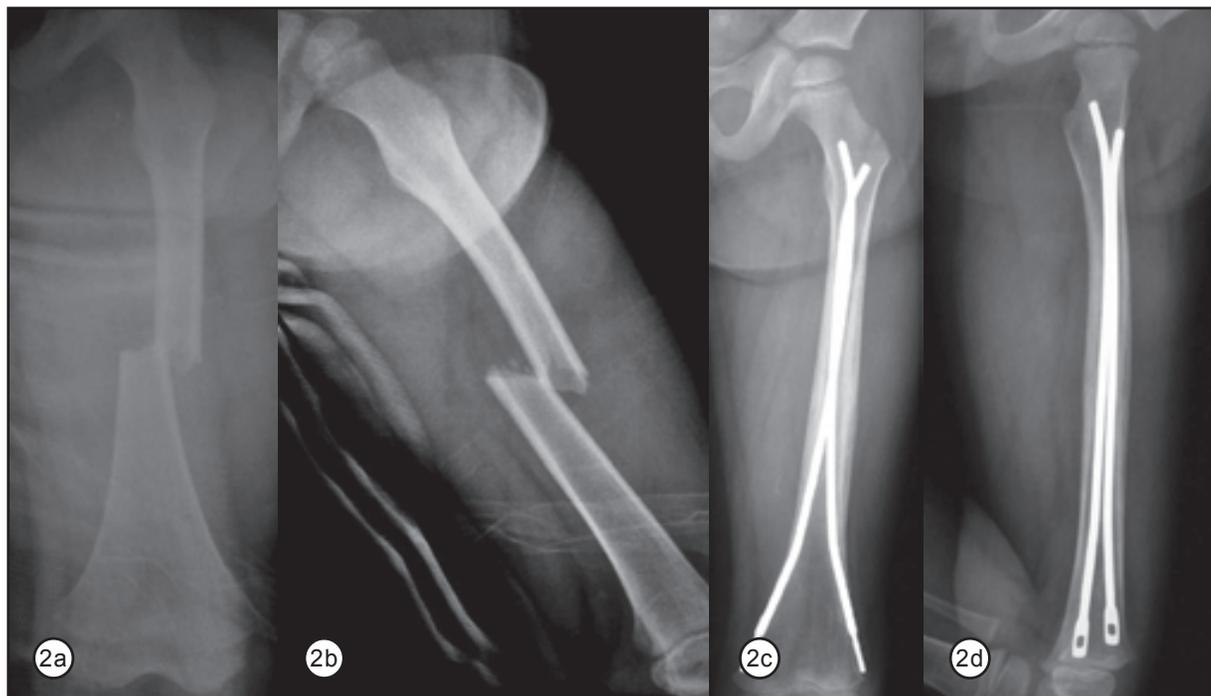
Pre-operative X-rays, Figure 2c & 2d: At 12 months post-operative X-rays showing good union
